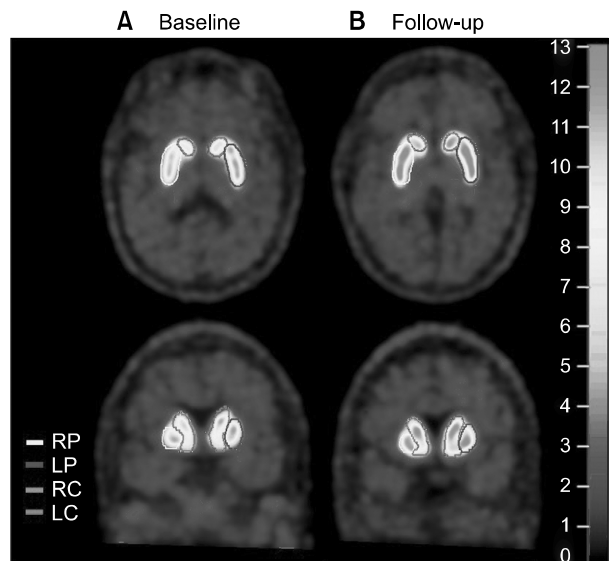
Representative [18 F]FP-CIT PET images of the patient. (A) The baseline RP, LP, RC, and LC SUV_{mean} were 7.50, 7.48, 6.72, and 6.84. (B) At eight-week follow-up, RP, LP, RC, and LC SUV_{mean} were 8.79, 9.03, 8.14, and 8.68.
